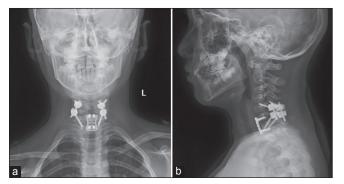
Postoperative (a) anteroposterior (b) lateral X-ray
